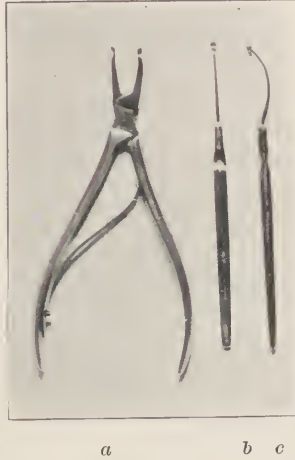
(a), Rongeur forceps; (b, c), periapical curettes.
